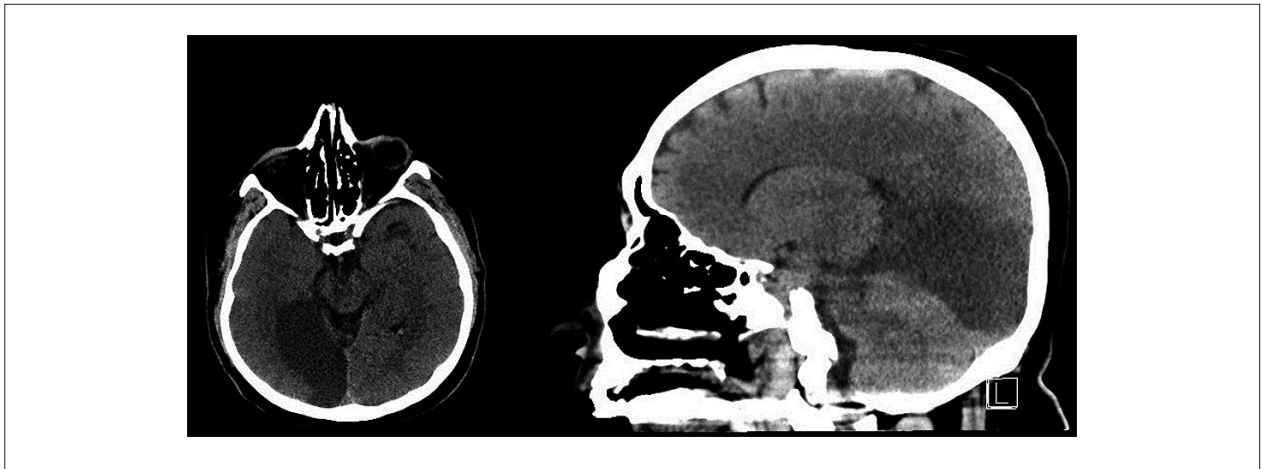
Subacute infarct in the right occipital and right posteromedial temporal lobe seen in the CT scan of the patient.
